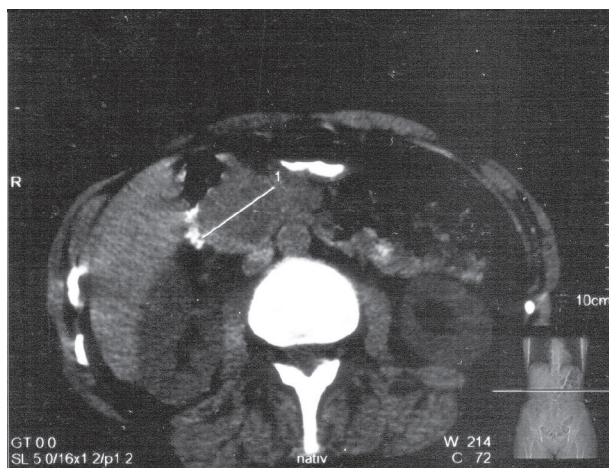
Computed tomography revealed a well-defined and circumscribed solid mass in the pancreas head.
